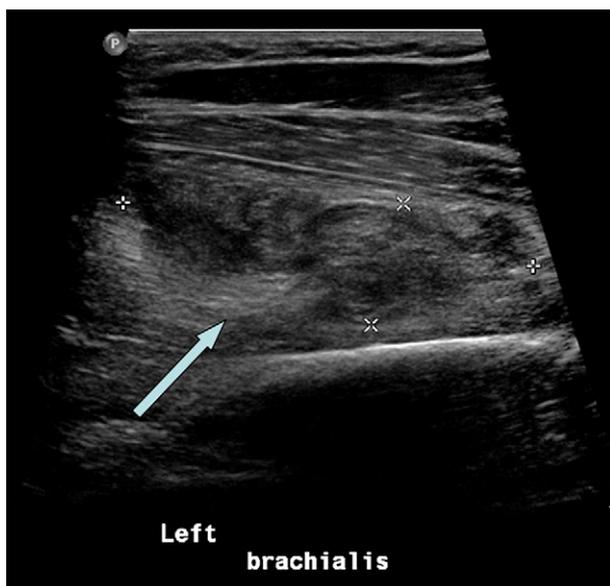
An ultrasound image of the elbow shows the ruptured brachialis (*arrow*).
